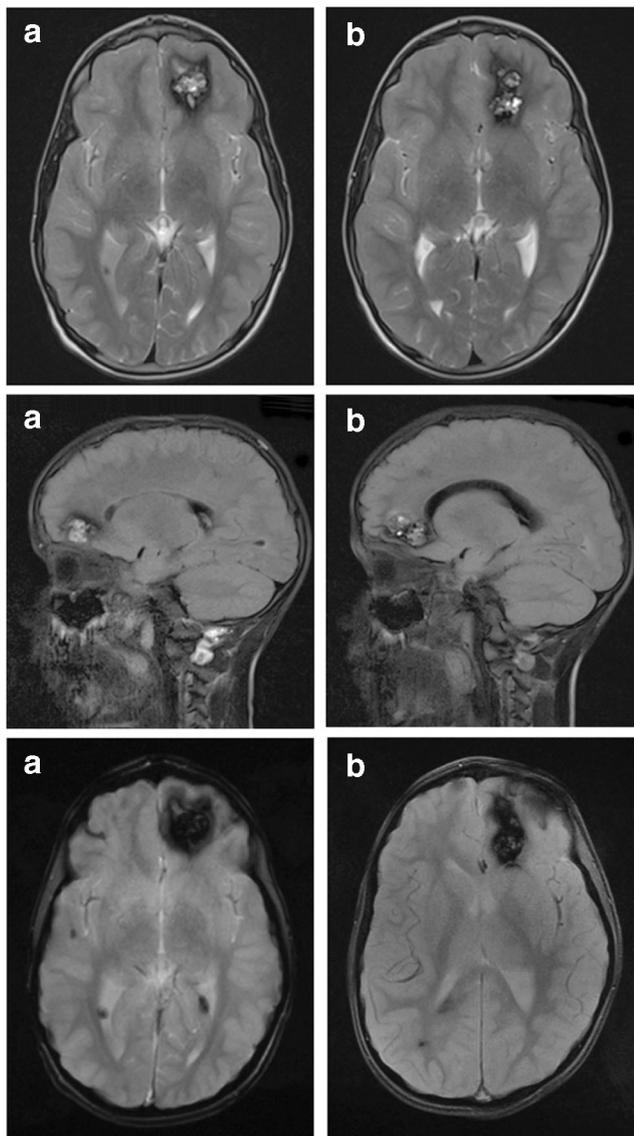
Axial T2-weighted (above), sagittal FLAIR-weighted (in the middle) and axial T2*-weighted (below) sectional MRI imaging of monozygotic triplet brothers depicting a symptomatic left frontobasal CCM with identical location and similar extension. On the left are MRI scans of the index patient A and on the right his brother B
